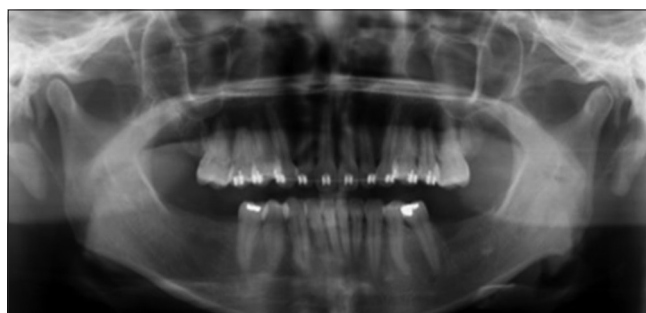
Case 1 panoramic film findings. Preoperative panoramic radiograph showing the elongated styloid process
